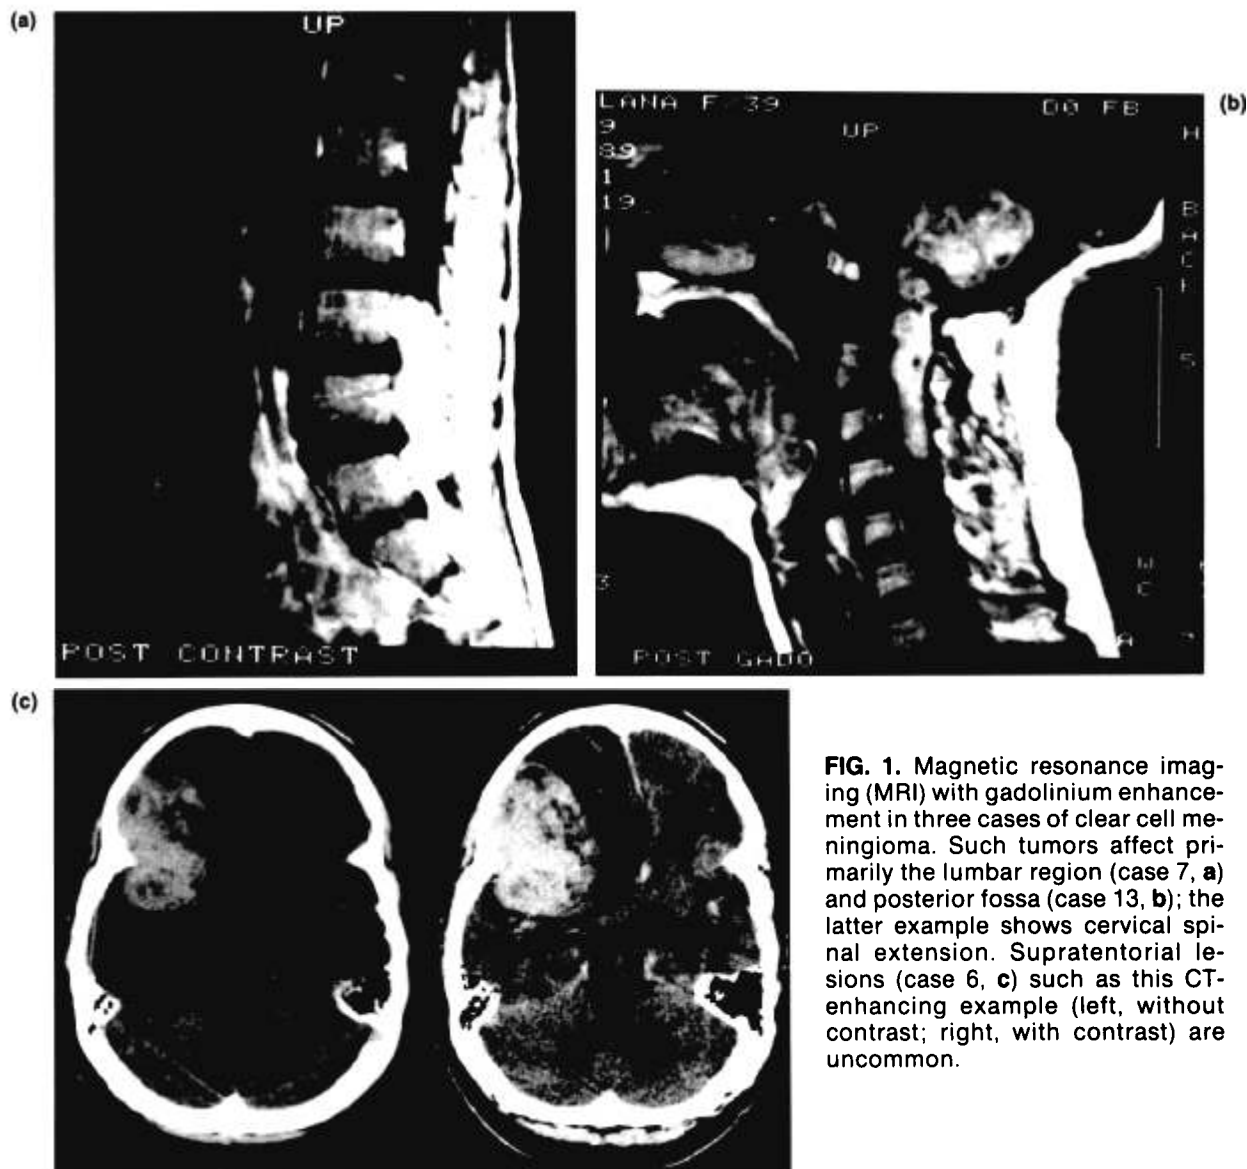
Magnetic resonance imaging (MRI) with gadolinium enhancement in three cases of clear cell meningioma. Such tumors affect primarily the lumbar region (case 7, a) and posterior fossa (case 13, b); the latter example shows cervical spinal extension. Supratentorial lesions (case 6, c) such as this CT-enhancing example (left, without contrast; right, with contrast) are uncommon.
